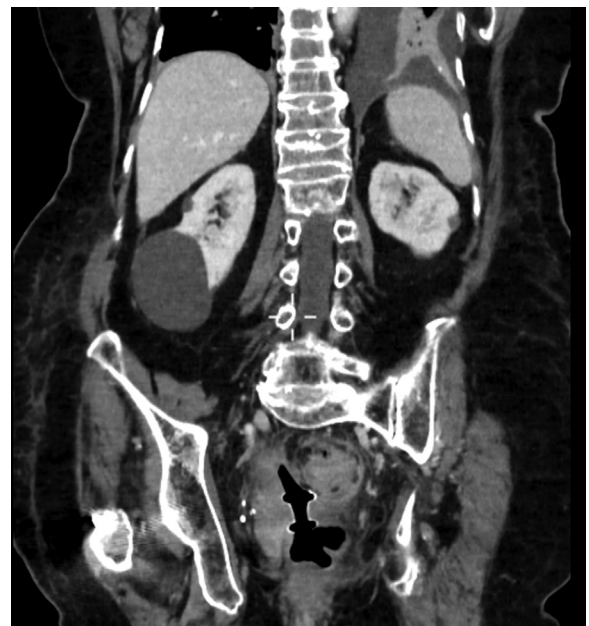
CT scan performed 3 weeks after EUS-guided transrectal drainage showing resolution of the collection and suspected stent proximal migration.
